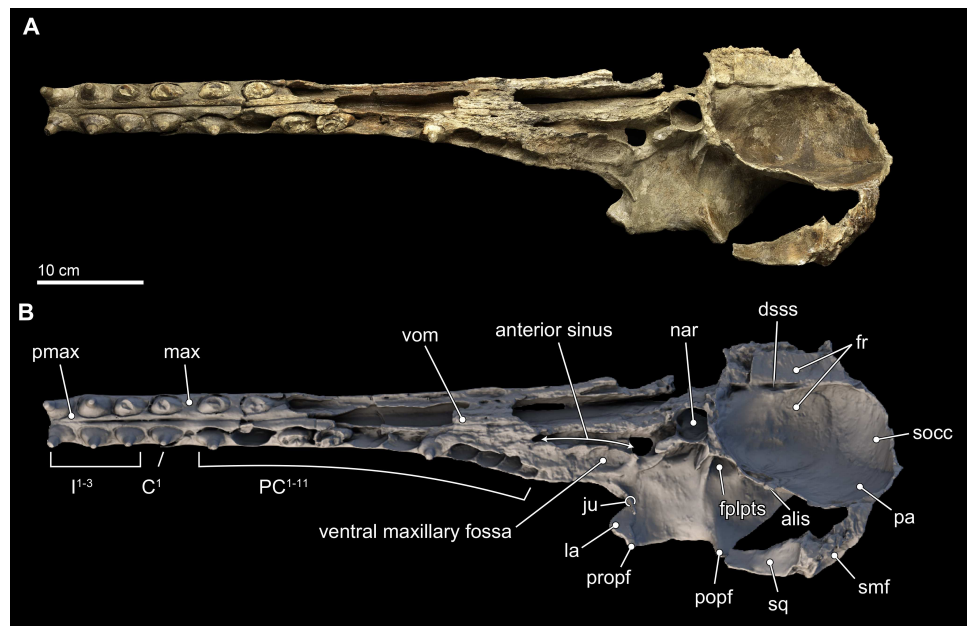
Skull in ventral view. Ventral views of the type skull of *Isthminia panamensis* (USNM 546125) from (A) photographs and (B) orthogonal digital three-dimensional polygon model prepared from CT data, with lighting and color modifications using the Smithsonian X 3D browser. See <http://3d.si.edu/explorer?s=iEpExr> to measure, modify, or download this model.
